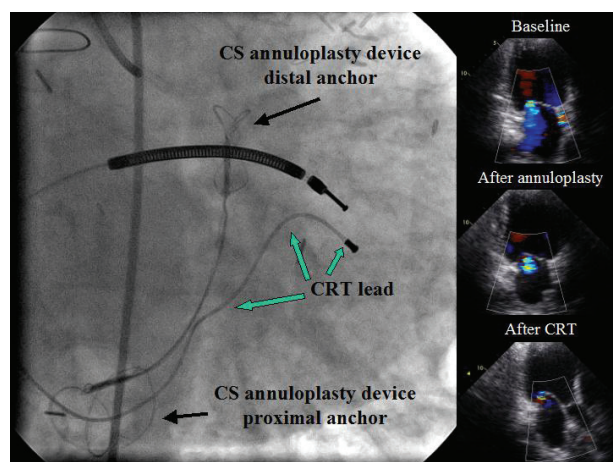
Left: Fluoroscopy of cardiac resynchronisation therapy (CRT) implantation in a patient after mitral annuloplasty with the Carillon™ device. Black arrows indicate Carillon™ anchors in the coronary sinus (CS) and great cardiac vein, green arrows show CRT lead. Right: Echocardiography at baseline, after mitral annuloplasty, and after CRT
